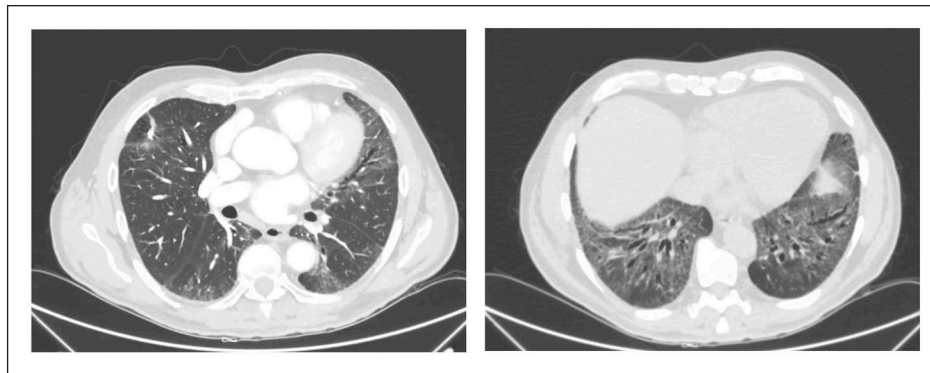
HRCT imaging showing bibasal ground-glass opacities, peribronchovascular fibrosis and bronchiectasias, compatible with NSIP pulmonary fibrosis pattern. Multiple hilar-mediastinal lymphadenomegalies are appreciable (maximum diameter of 26 mm × 9 mm in subcarinal location and approximately 20 mm × 9 mm in right paratracheal location). Two rounded lingular nodules (maximum diameter 6 mm, stable) and a subpleural micronodule of 3 mm diameter in the posterior segment of the upper right pulmonary lobe were both known from the previous HRCT.
